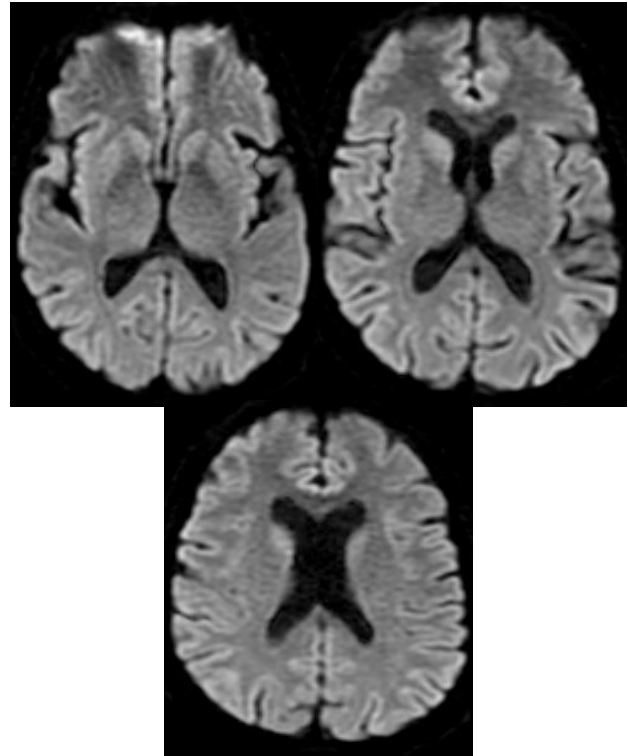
Post treatment DWI show complete resolution of the abnormal areas of restricted diffusion in corpus callosum and parietal white matter.
